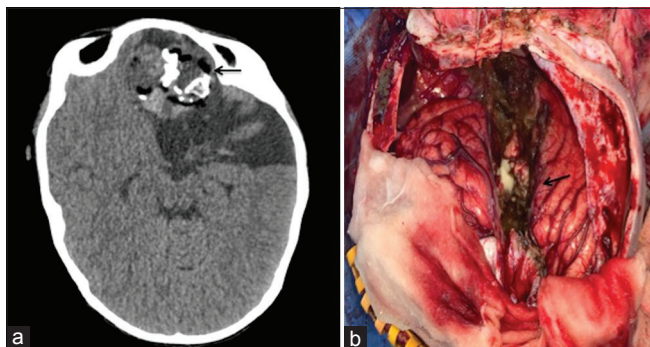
Axial NCCT Brain (2a) section corresponding with the MRI sections reveals presence of fat as well as calcifications in the areas of hypointensity on SWI [Figure 1d]. Intraoperative image [Figure 2b] shows presence of cheesy material and soft tissue mass in the midline. NCCT- non-contrast computed tomography and SWI- Susceptibility weighted imaging.
